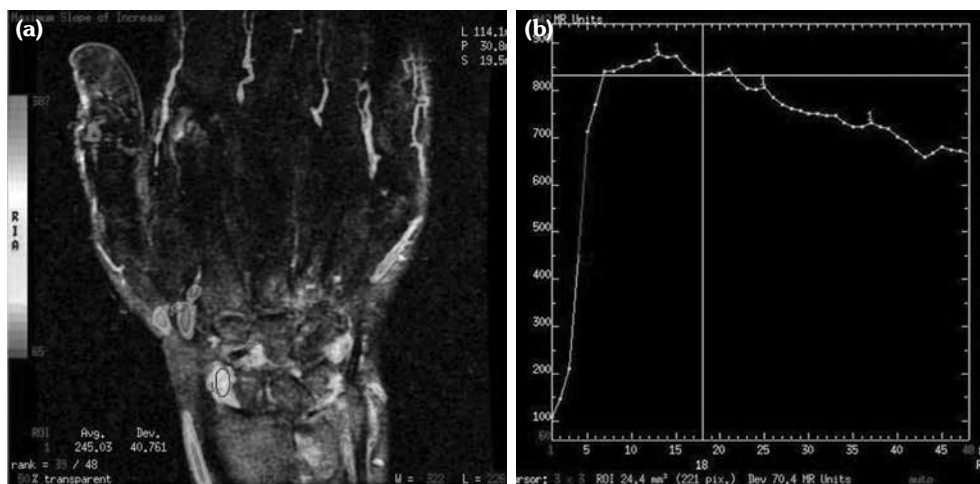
(a) Color map of wrist dynamic contrast-enhanced magnetic resonance imaging and (b) 48-phase signal time curve.
